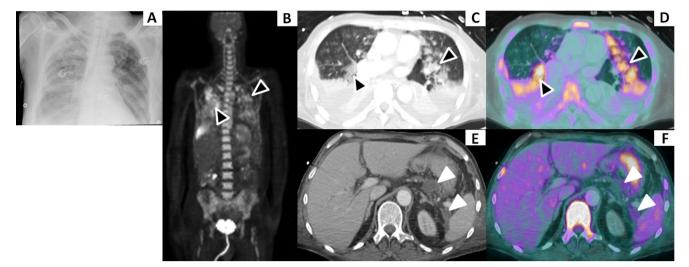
In this 59-year old patient, admitted for pancreatitis 38 days before (#1 in Table 1), FDG-PET images revealed bilateral pneumonia with concordant images from CTA (*black arrowheads*; b: anterior view of a 3D-MIP from FDG-PET; c: CTA images d: fused FDG-PET and CTA images). FDG-PET images also ruled out abdominal infection, revealing no hypermetabolism of the collections lying in the pancreatic region
